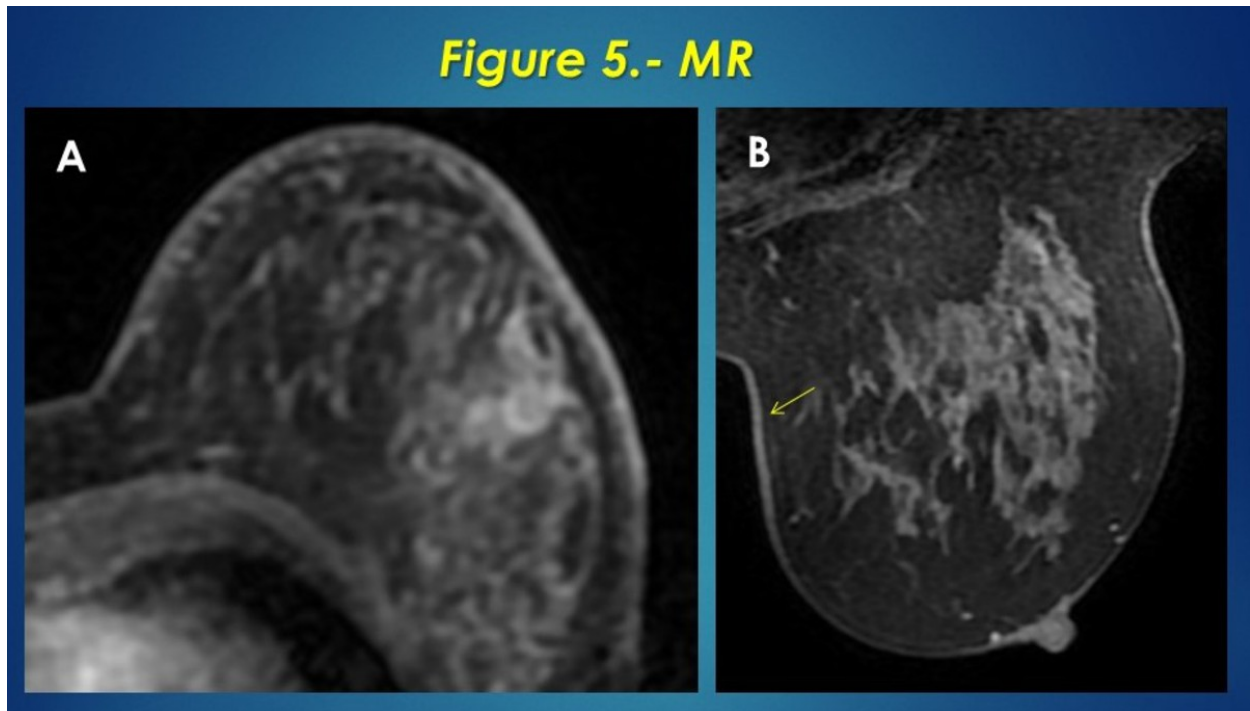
Fig 5. MR. A T2-weighted axial image. Skin edema appears as thickened hyperintense skin. B Axial T2-w.Normal skin Slight enhancement (arrow)
